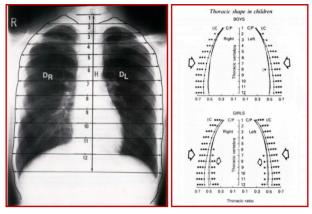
Left figure - Chest radiograph to show the method of measurement for calculation of thoracic ratios (TR) fromT1-T12. DR (DL) = distance measured from midpoint of the distal end-plate of each vertebral body (Tl- 12) to the outline of the lateral border of the right (left) thoracic cage. H = distance from Tl- 12. Right figure - TRs for infancy (I), childhood (C) and puberty (P). (Modified from Grivas et al 1991). [38].
